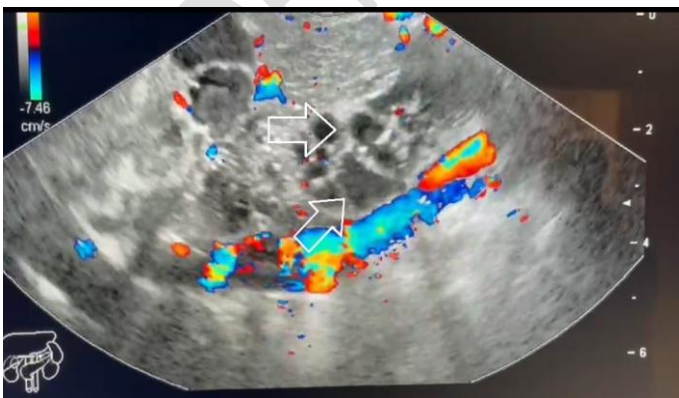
EUS with Doppler flow in vessels and multiloculated cystic lesion with apparent honey-combing
